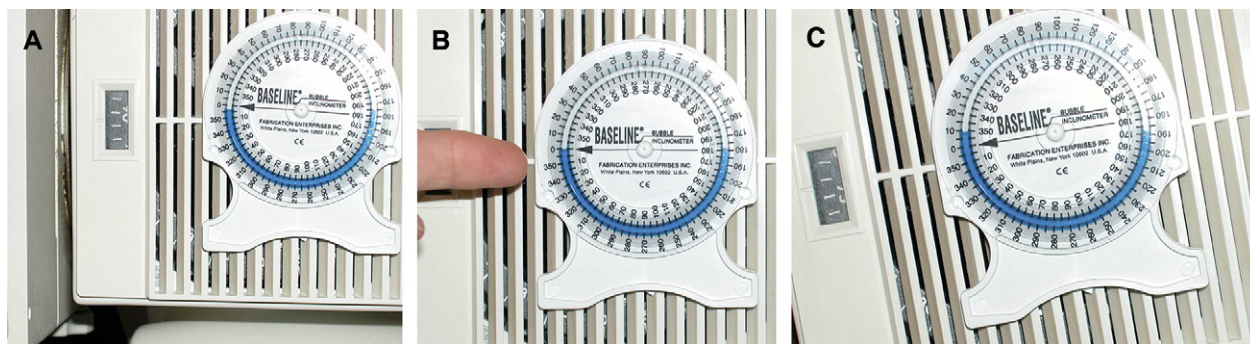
X-ray head angulator calibration with a bubble inclinometer. (A) The bubble inclinometer is Velcro fastened to the X-ray head (left figure) with the head in the horizontal position. (B) The calibration dial is rotated to place the arrow at zero (right figure) prior to adjusting the head angle. Note the coarse indicator on the equipment to the left of the bubble inclinometer and the fact that the indicator is not accurately calibrated. (C) The head angle is read at the bottom of the concave air/blue water interface (see red arrow). Here we see a 9° caudal head angle. Again note the inability to determine the head angle on the actual equipment (and its lack of calibration).
